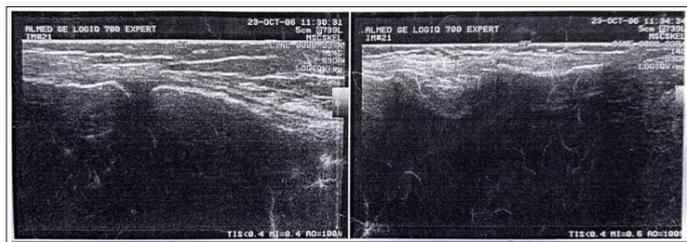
Ultrasound Examination of the Left Knee Joint Demonstrated Chondromalacia of the Patella, Grade I–II Cartilage Defects, Osteophytic Deformities of the Tibiofemoral Joint and Abnormalities of the Distal Femoral Metaphysis
